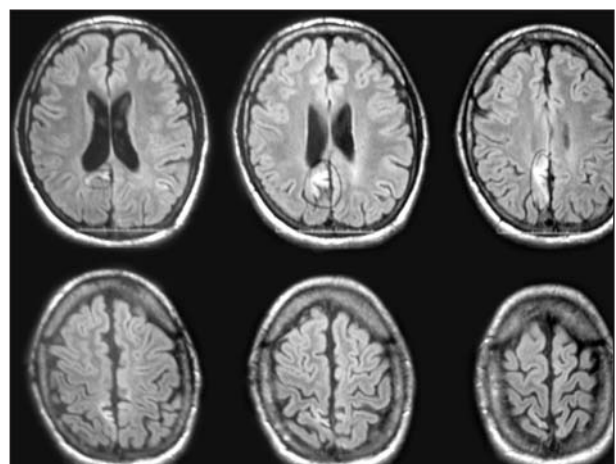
Flair sequences of the brain MRI of the patient showing right mesial parietal cortical dysplasia.
